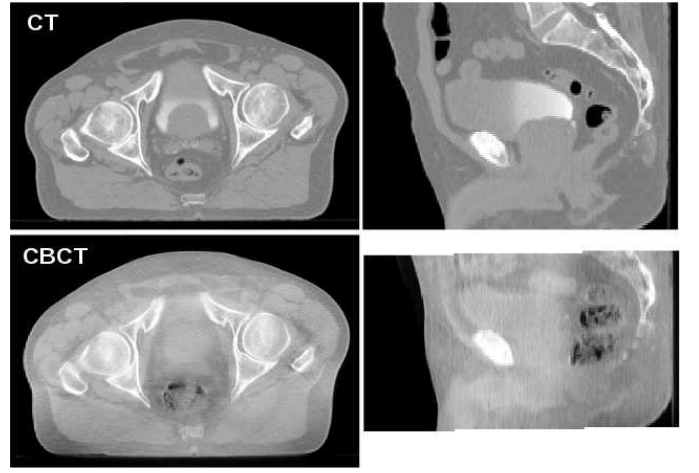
Top: Axial and sagittal slices of a planning CT example. Bottom: Identical corresponding slices of a rigidly registered daily CBCT
